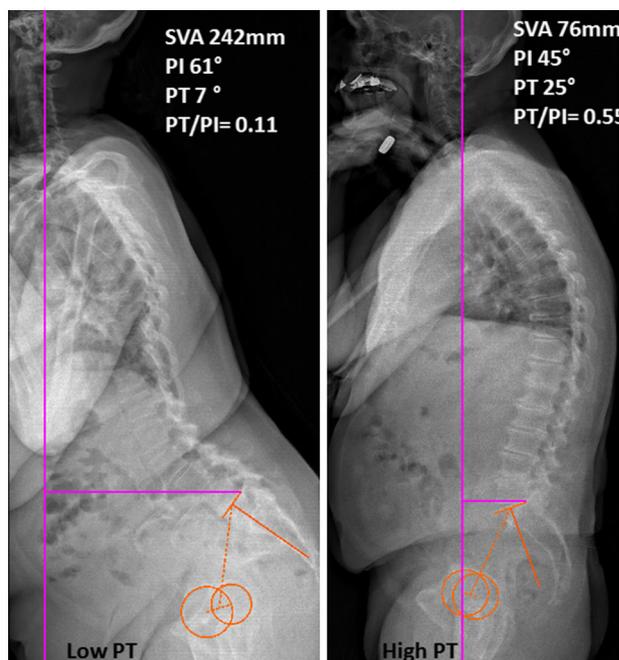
Sagittal x-rays of a LowPT and a HighPT patients with SVA and pelvic parameters
